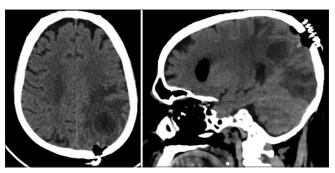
Postoperative computed tomography scan showing the biopsy tract up to the lesion
